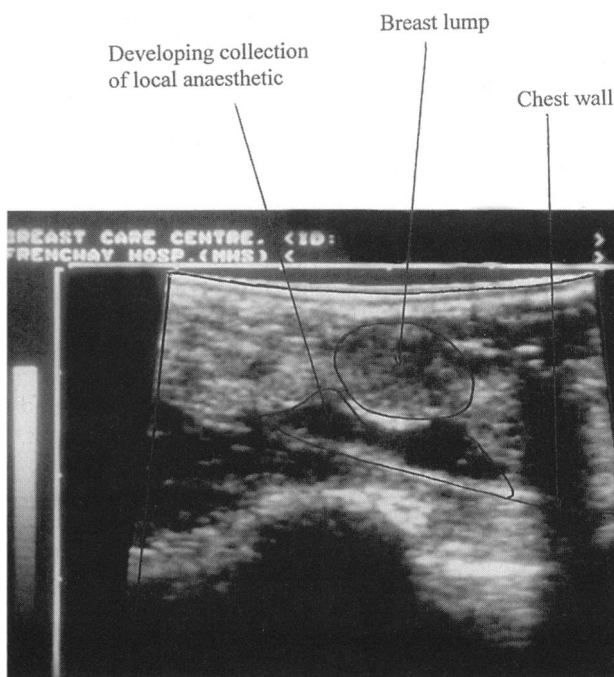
Ultrasound scanning to guide anaesthetic injection.
